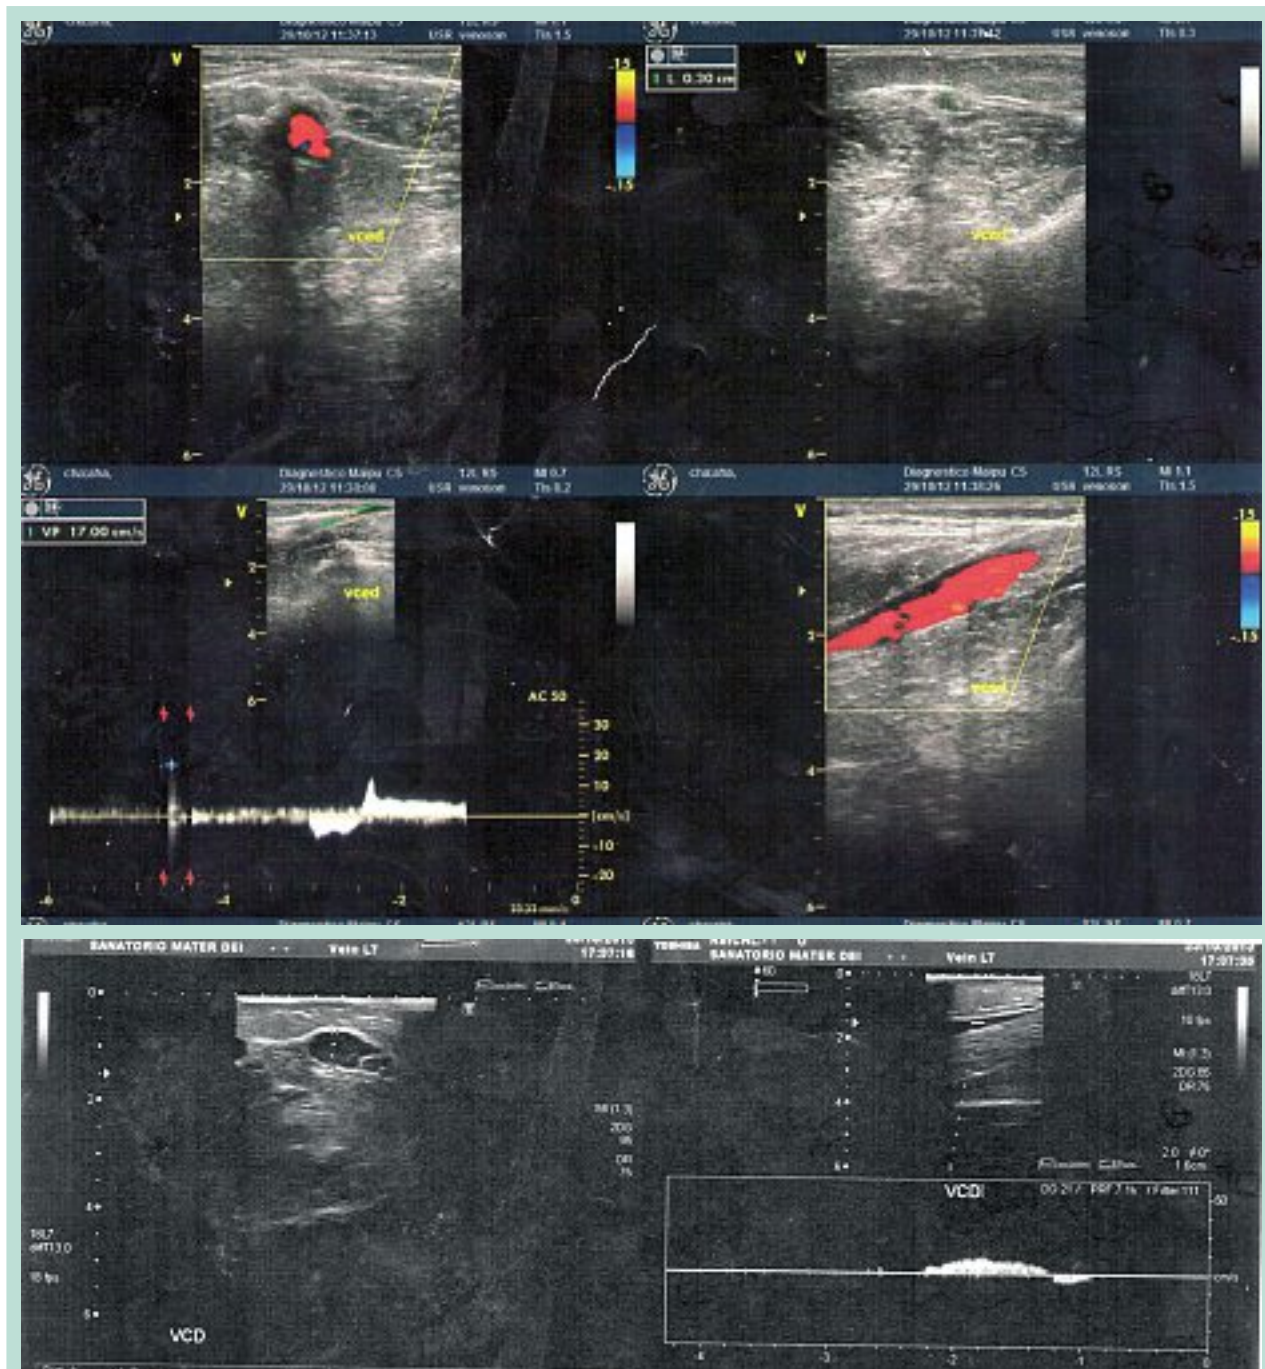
Doppler ultrasound study showing varicose veins of the sciatic nerve with reflux.
